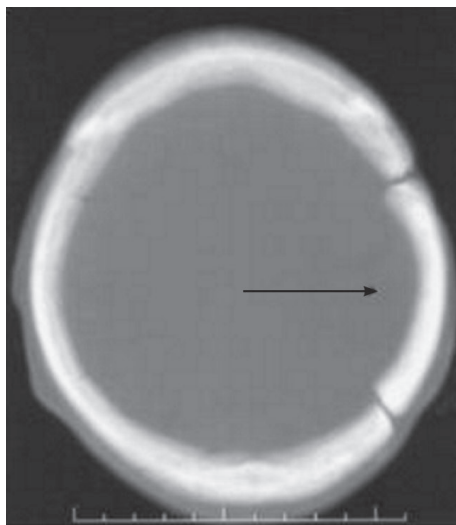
CT sequence (ante mortem) of the skull shows localization of trepanation.
